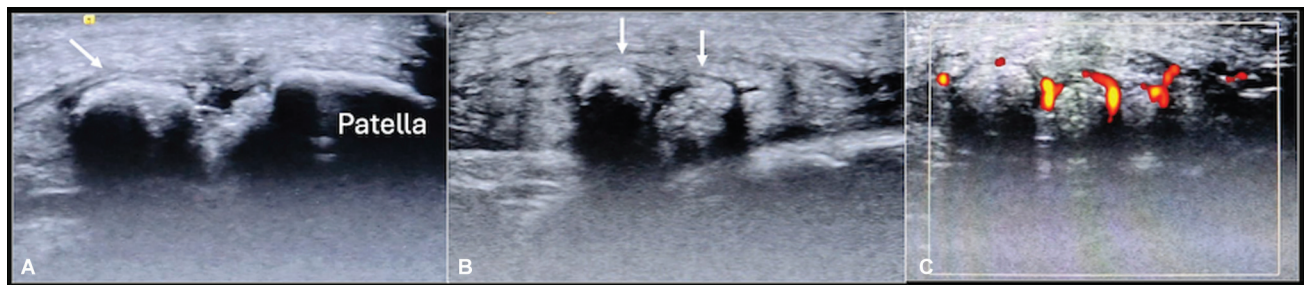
Short axis (A, B) ultrasound of knee shows multiple foci of calcification (arrow) in relation to the lateral patellofemoral ligament (LPFL) with mild increased signal on Doppler (C).
